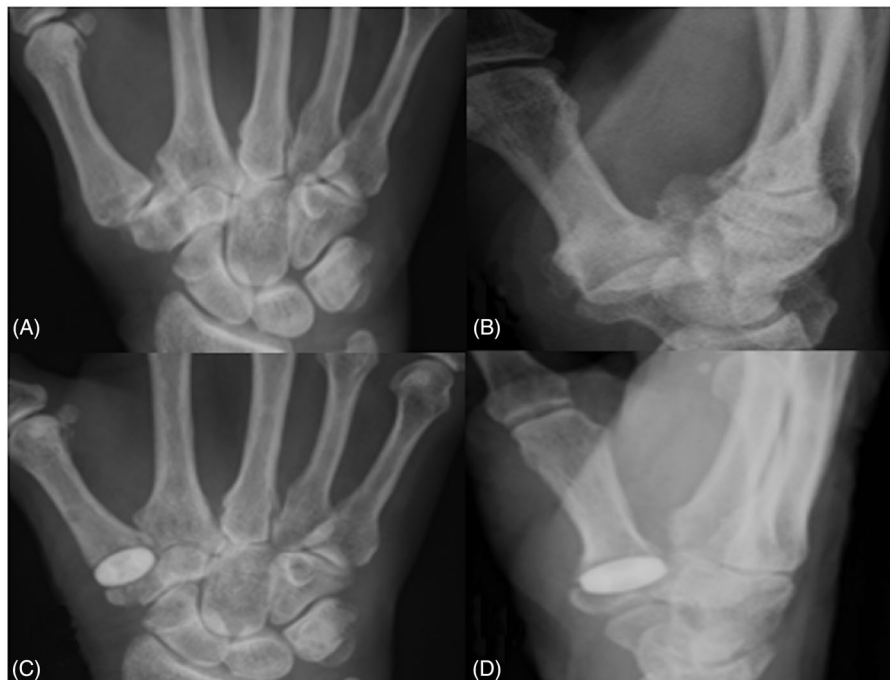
Sagittal (A–C) and coronal (B–D) radiographs of a stage II rizoarthrosis according to Eaton–Little classification preoperatively and at 66 months follow-up, following a trapeziometacarpal arthroplasty with Pyrodisk. The implant is well positioned, and no sign of implant loosening are seen.
